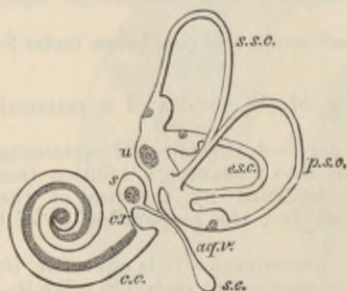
PLAN OF THE RIGHT MEMBRANOUS LABYRINTH VIEWED FROM THE MESIAL ASPECT. $\frac{2\frac{1}{2}}{1}$
